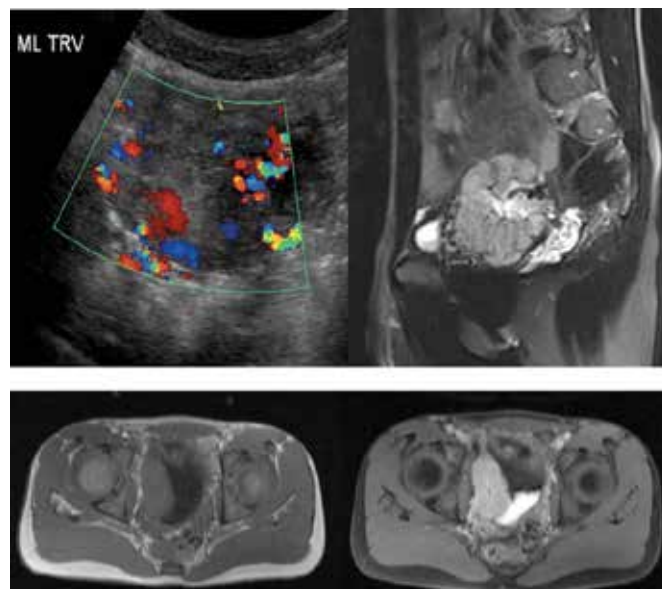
Imaging findings in a 15-year-old boy with hypertension secondary to bladder paraganglioma. (a) Midline color Doppler US image of a moderately full urinary bladder shows a round soft tissue mass on the right lateral wall of the bladder, with marked vascularity. (b) Sagittal fat-saturation T2-weighted MR image shows a tortuous vessel leading to the lesion. (c, d) Axial without contrast (c) and saturated fat with contrast (d) T1-weighted MRI images obtained at the level of the urinary bladder show hypersignal of bladder wall injury.⁴
